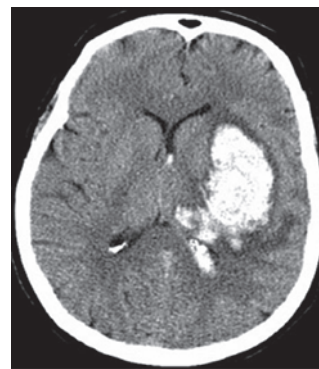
CT scan of brain shows hyper-density in the left intra-parenchymal region suggestive of hemorrhagic stroke.
